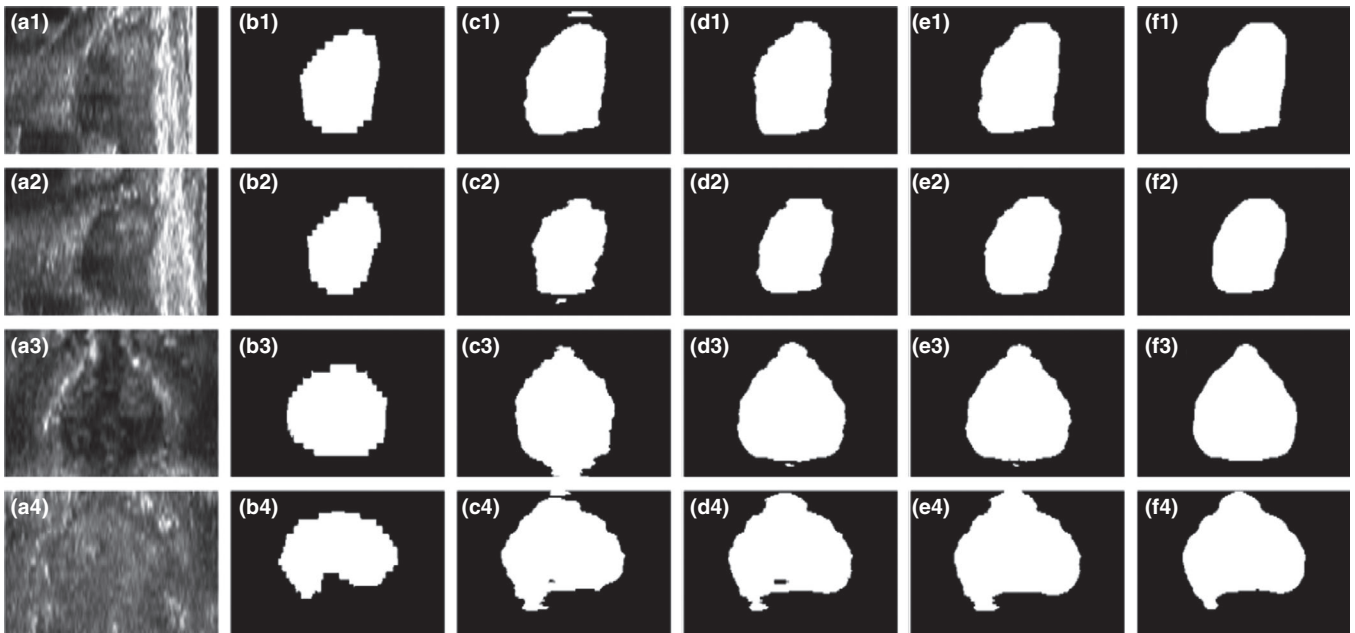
Comparison of segmented prostates with and without multidirectional-based refinement. (a1–a2) Transrectal ultrasound (TRUS) images shown in sagittal plane, (b1–f1) and (b2–f2) corresponding manually contoured prostates, the segmented prostate from transverse, coronal, and sagittal planes, and the segmented prostate with the multidirectional-based refinement, respectively. (a3–a4) TRUS images shown in coronal plane, (b3–f3) and (b4–f4) Corresponding manual contour, the segmented prostate from only transverse, coronal, and sagittal planes, and the segmented prostate with the refinement, respectively. The display window size of (a1–a4) is [0, 200].
